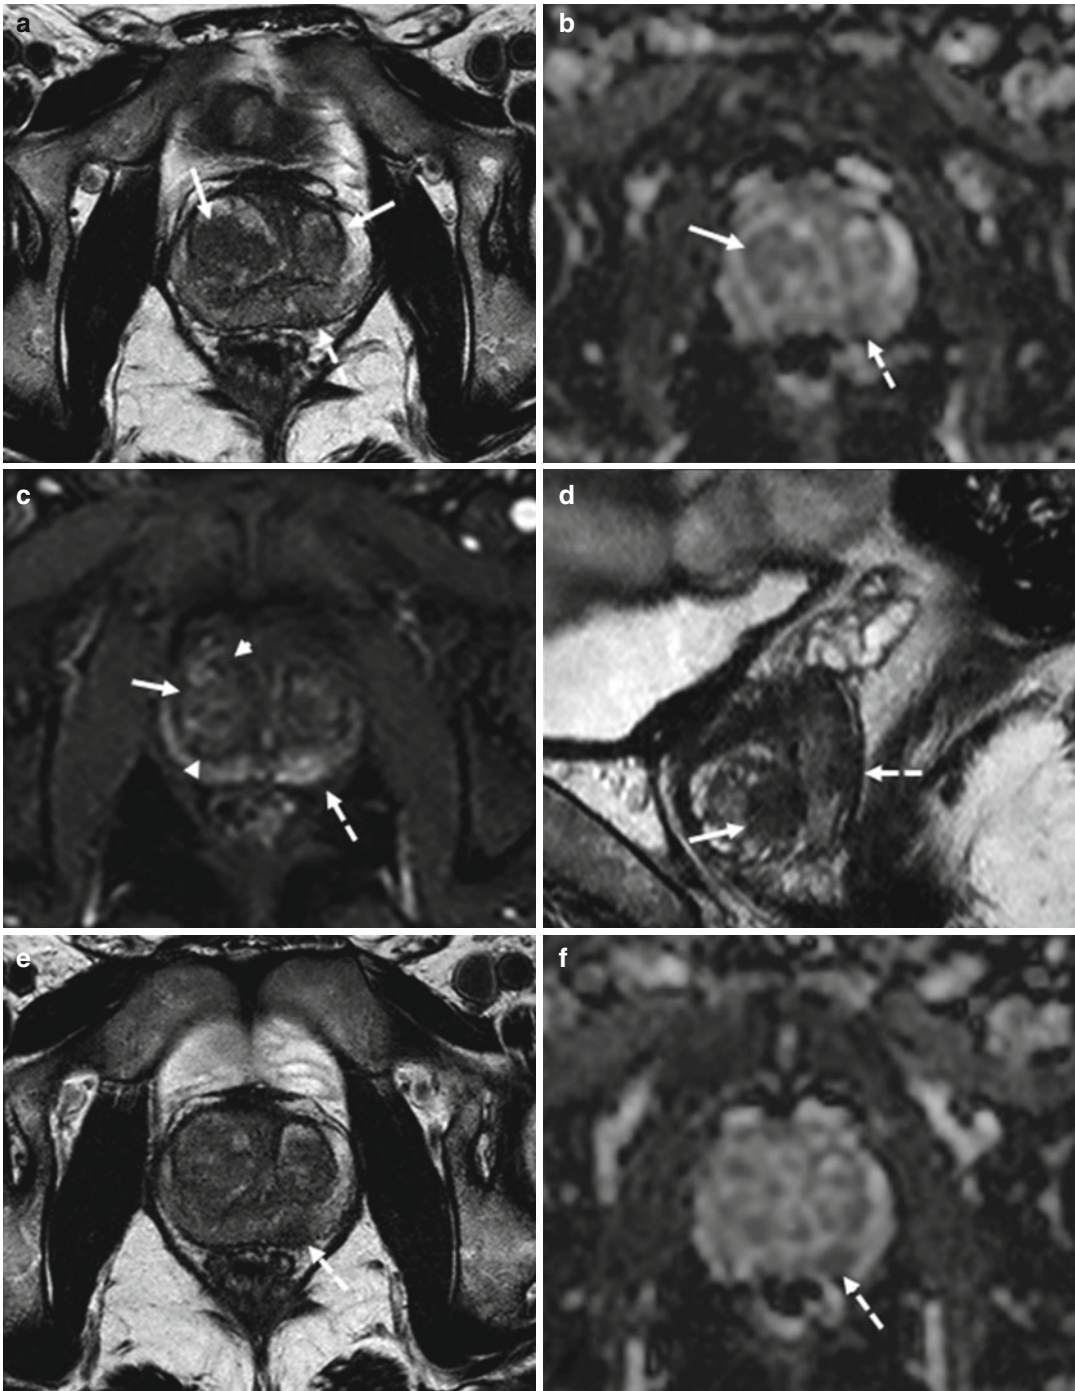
(a–f) 56 years old, PSA 9.2 ng/ml, Gleason 6 (3+3). On axial T2-weighted (TR: 4074; TE: 100) sequence (a), the transition zone appears inhomogeneous because of the presence of two large hypointense nodules (arrows). On ADC sequence (b), the right nodule is clearly recognizable, appearing hypointense (arrow), while is quite vascularized on post-contrastographic phase (c), bounded by a hypointense edge (arrowheads). The left nodule is better appreciable at a lower axial plane (not shown) and on sagittal
